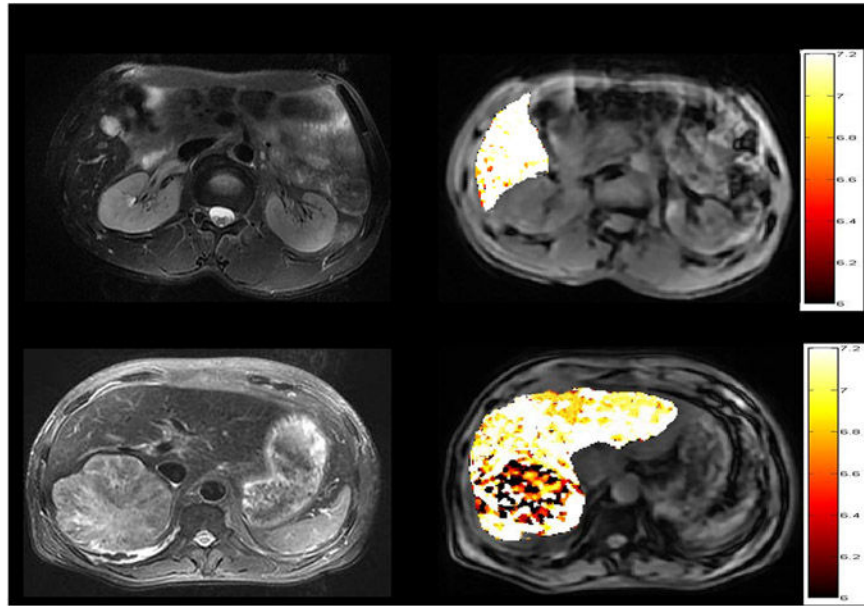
Liver pH imaging with CEST MRI of Ioversol. a) A structural image of a hepatic hemangioma patient. b) pH map shows consistent pHe with the surrounding normal tissue. c) A structural image of a hepatic carcinoma patient. d) Tumor pH map is noticeably lower than normal tissue (Tang et al. *Frontiers in oncology* 2020;10:578985.)
